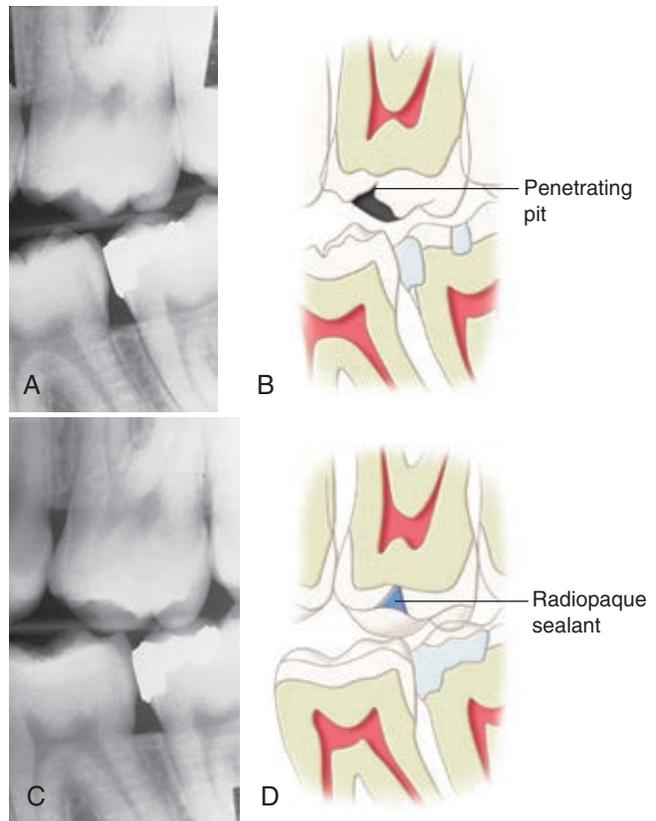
A and B, Radiograph of a maxillary first molar with a deep central fossa pit that appears to penetrate to the dentin. C and D, The central pit was sealed with a highly filled, radiopaque sealant. The sealant is readily visible on the radiograph.
